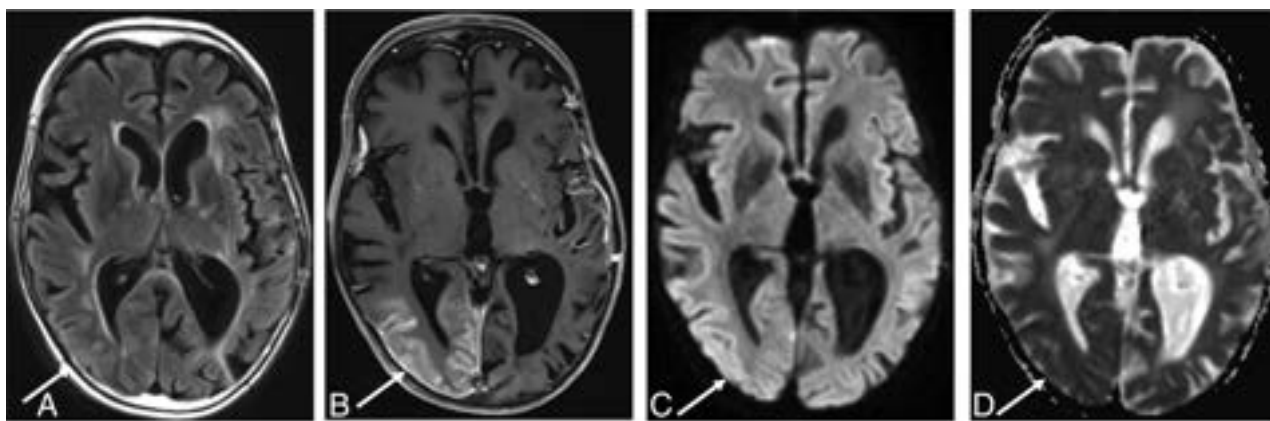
A 51-year-old man with a history of juvenile left posterior fossa tumor treated by surgery and whole-brain irradiation 45 years ago presented with acute visual changes and seizures. He was diagnosed with SMART syndrome and treated with corticosteroids and recovered from the symptoms. A FLAIR image (A) shows cortical hyperintensity, and the postcontrast T1 image (B) shows gyriform enhancement in the right temporo-occipital region (arrows), with an incidental right temporal dural-based meningioma. There is high signal on diffusion-weighted imaging (C) without low signal on ADC (D) (facilitated diffusion) (arrows).
